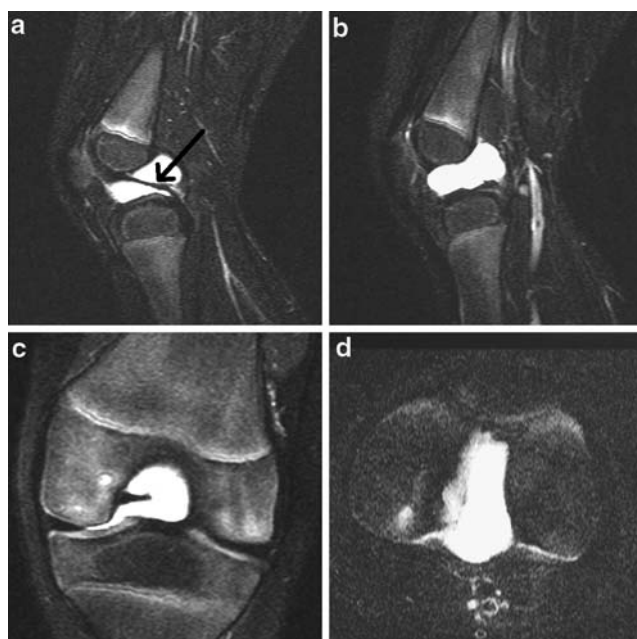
Pre-operative T2-weighted sagittal (a) and (b), coronal (c), and axial (d) MRI images demonstrating extensive intra-articular cystic structure. The cyst envelops the PCL *arrow* in (a). The ACL was not visualized on MRI
